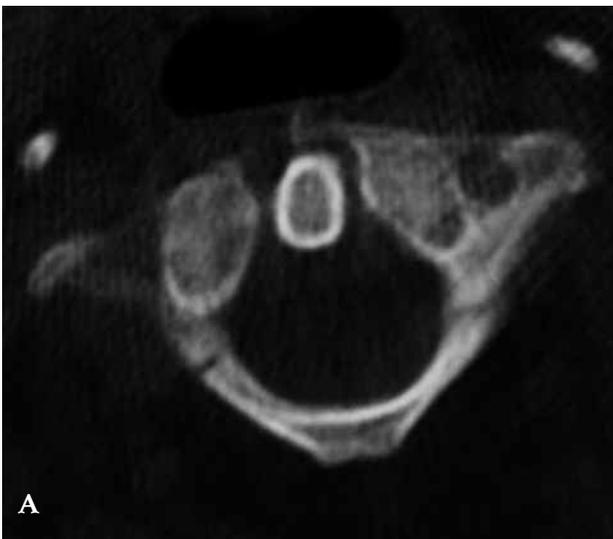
A-B: Bilateral fracture at posterior arcus of C1 and a coronally orientated vertical C2 corpus fracture are seen at axial CT.
